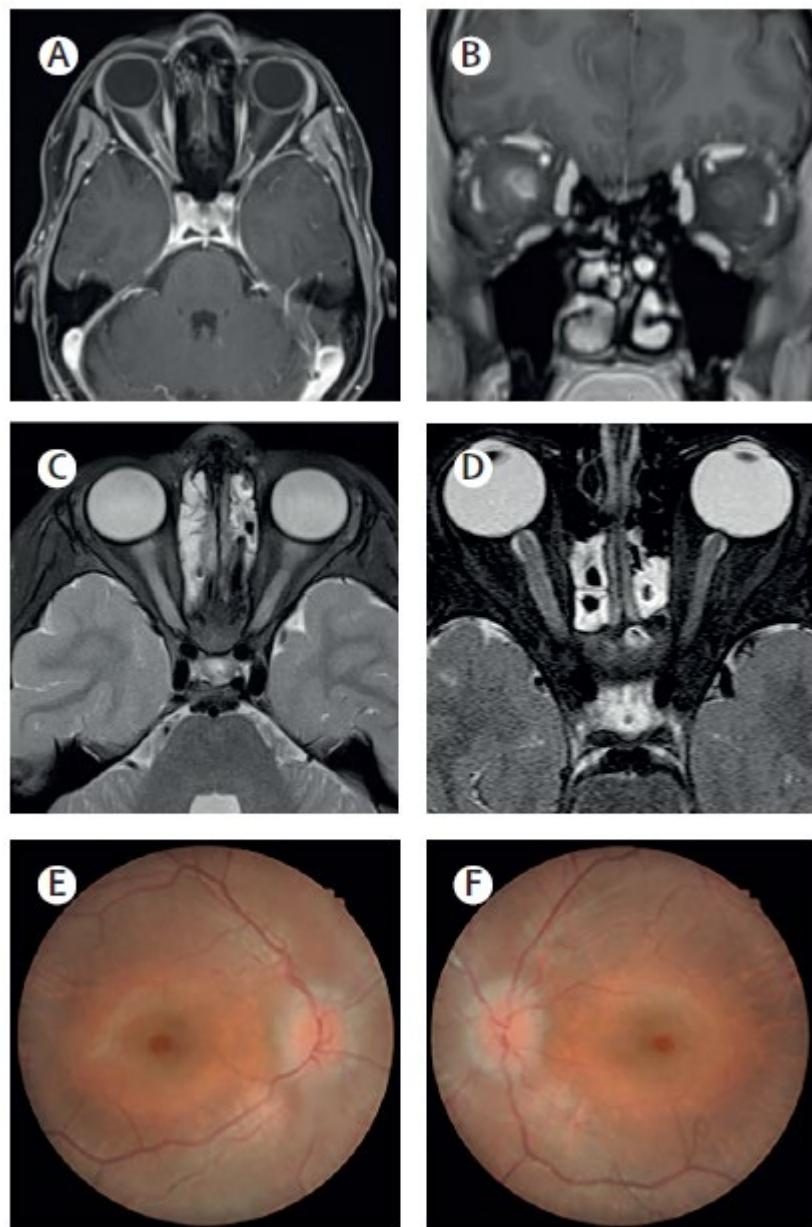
MRI and fundoscopic lesions in MOGAD: [8]
